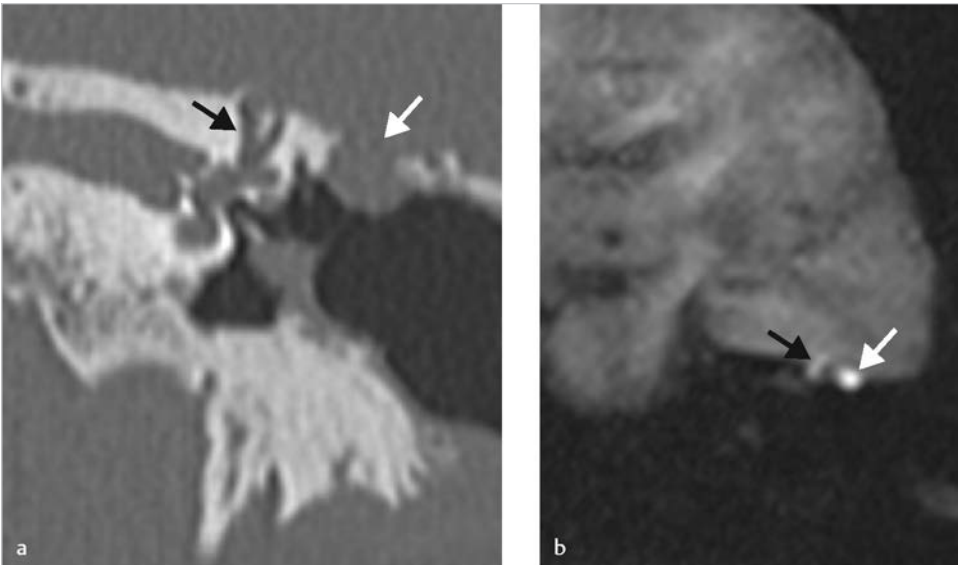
The coronal CT (a) shows presence of soft tissue eroding the tegmen of the antrum (white arrow), infiltrating medially to the superior semicircular canal to erode its ampulla (black arrow). A coronal section of diffusion-weighted image of MRI (b) shows high signals in both area indicating presence of cholesteatoma.
